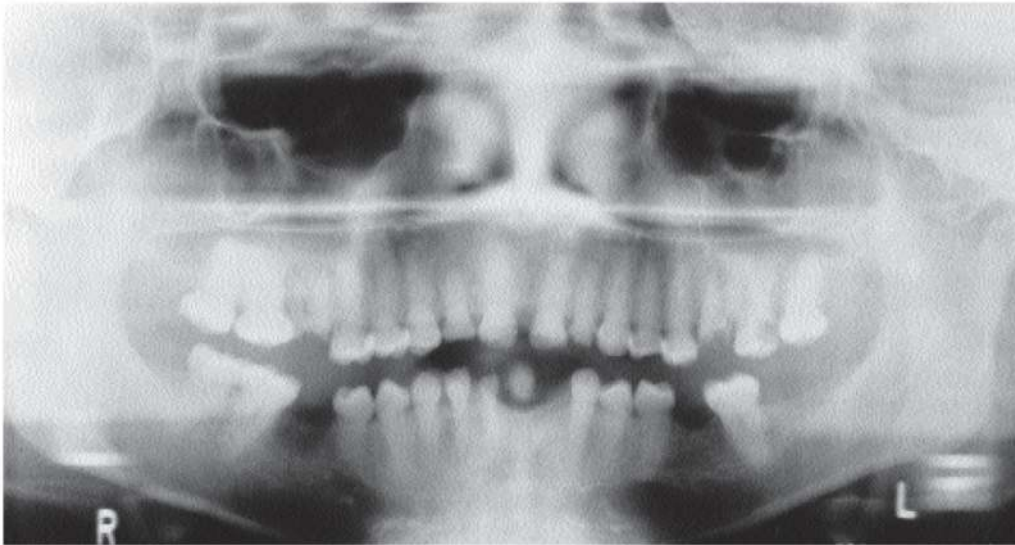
Panoramic radiograph showing complete obliteration of the pulp excepting 37 and 47.
